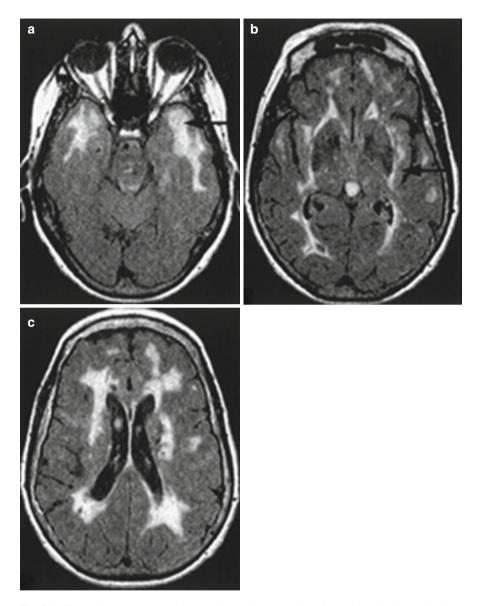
Cerebral MRI scan showing extensive white matter hyperintensities (leukoencephalopathy) and multiple lacunar lesions. The white-matter hyperintensities were located periventricularly and in frontal, parietal, and temporal lobes of both hemispheres. There was also involvement of the external capsules (a) White matter lesions in the anterior temporal lobe (*arrow*), typical for CADASIL; (b) involvement of the external capsule (*arrow*); (c) extensive bilateral leukoencephalopathy with subcortical lacunar infarcts
